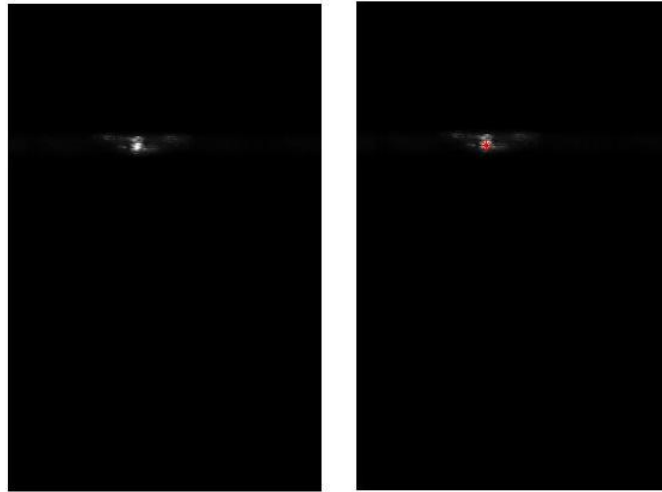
A sample ultrasound calibration image with the pointer tip visible and red point in the right image is the point detected through auto-segmentation
